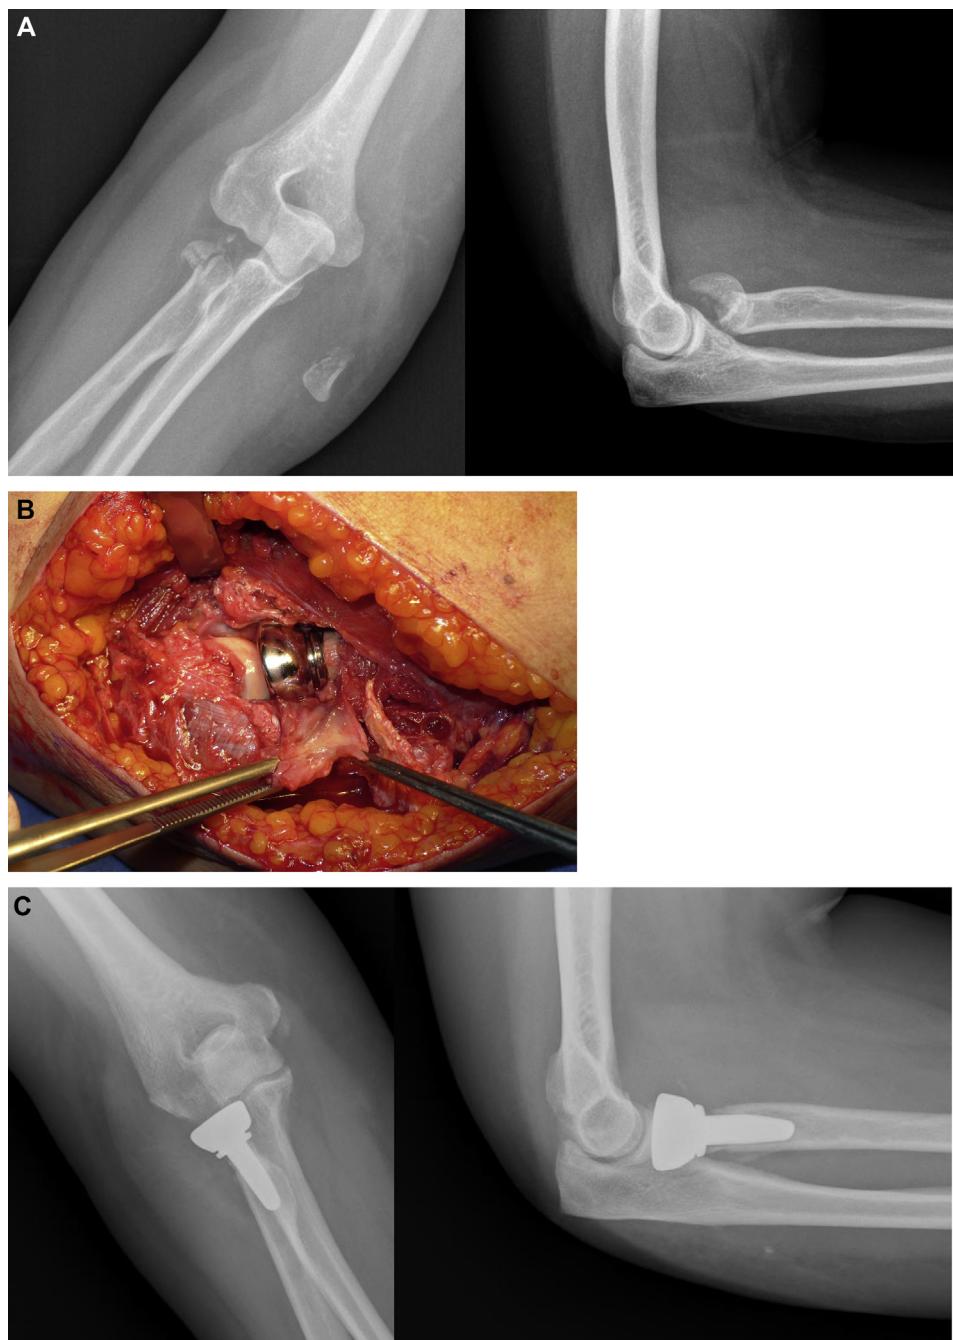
A. X-rays showing fracture of the radial head with dislocation of fragments. B. Intraoperative view of the anatomical radial head implant and the lateral ulnar collateral ligament (LUCL) ligament detached from its condylar insertion. C. X-rays at 6 months after surgery showing minimal stress shielding around the neck.
